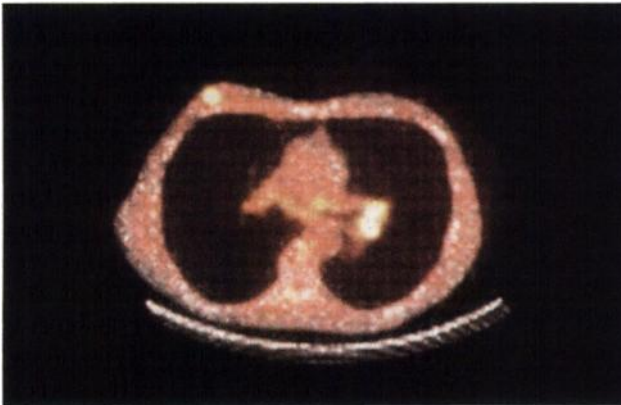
By means of "Fused Image Tomography" (FIT), the lesion that accumulates FDG can be localized as being in the breast rather than the chest wall or ribs.
